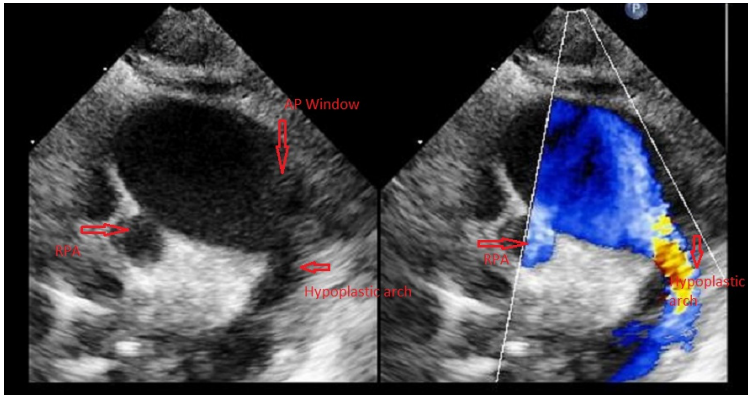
High parasternal transthoracic image with color comparison showing hypoplastic arch continues from the large AP window trunk and showing branch pulmonary artery from the posterior portion of trunk. (RPA-Right pulmonary artery, AP window-Aortopulmonary window).
